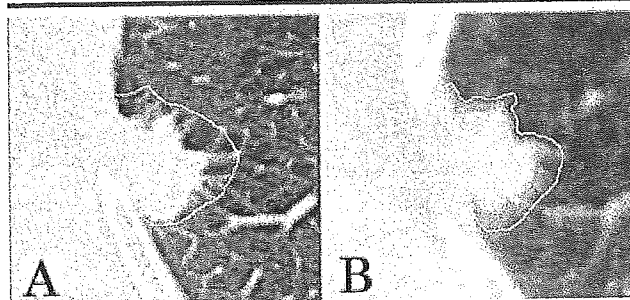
A, Transverse thin-section CT image shows tumor with surrounding spiculation that indicates traction-related emphysematous change. B, Transverse long-scan-time CT image shows ill-defined margin of tumor with lower attenuation than that on thin-section CT images, a factor that could lead to accidental omission of part of the tumor margin from the target volume. In delineation of tumor margin on long-scan-time CT images, careful reference to tumor features on thin-section CT images is required.
